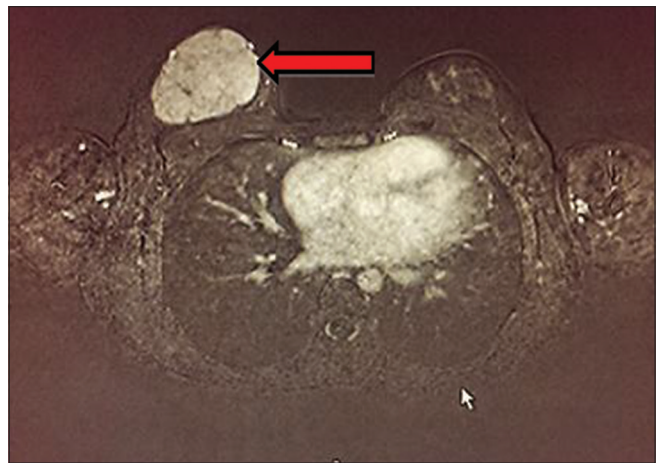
Axial cut of magnetic resonance imaging of the breast
